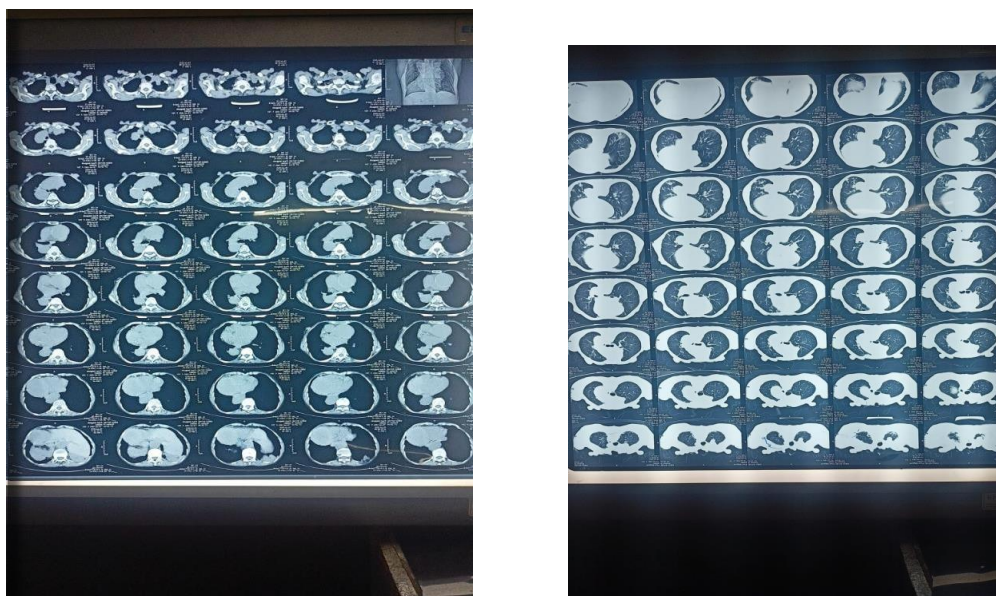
HRCT lungs showing bronchopneumonia and revealing ascending aorta aneurysm as an incidental finding.
